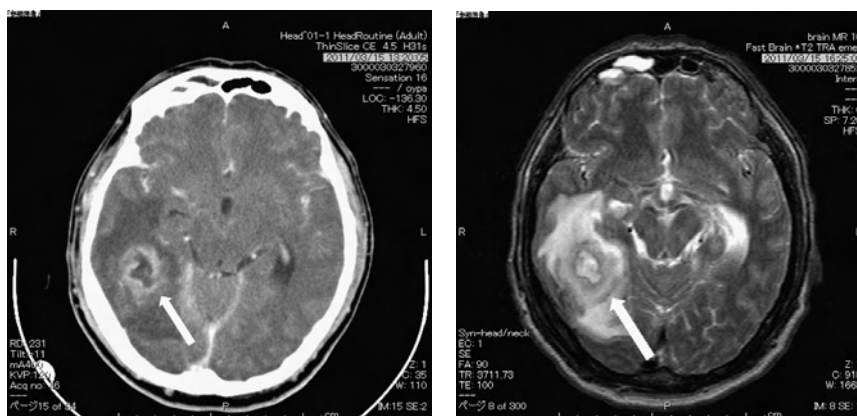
A. Axial section CT at second admission. Brain abscess in the right temporal lobe (arrow). B. Axial section MRI at second admission. Brain abscess in the right temporal lobe (arrow).
